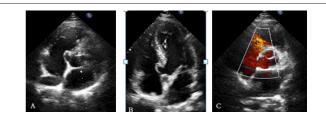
(A, B, C): In TTE, in 4-chamber view, a perimembranous VSD which is restricted by septal leaflet of tricuspid valve is seen (Figure A). In 4-chamber view, the distance of the larger defect to the aortic valve is demonstrated (Figure B). In color echocardiography, 2 residual defects (a large one and another small one) is visualized (Figure C).
